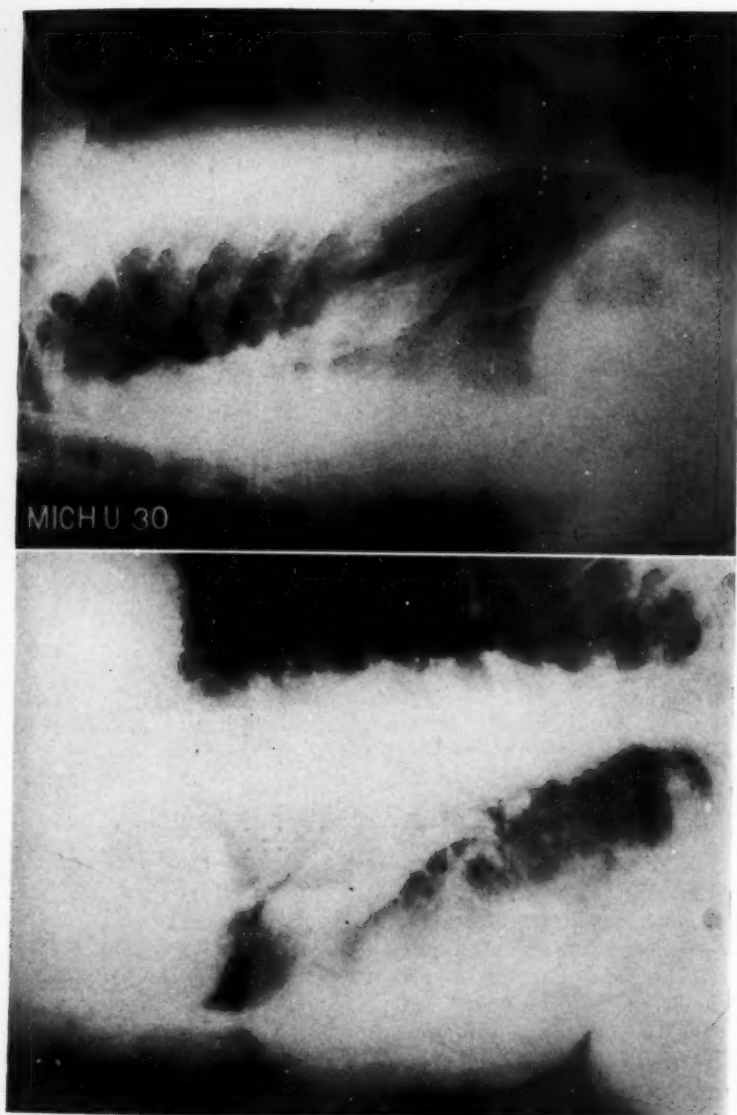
Case 5. Right and left lateral decubitus roentgenograms. These decubitus films show the level of the left hemidiaphragm to be normal, and the layer of density between the stomach bubble and the left lung base is considerably reduced. In this position some of the fluid has spilled out of the basal pleural space.
